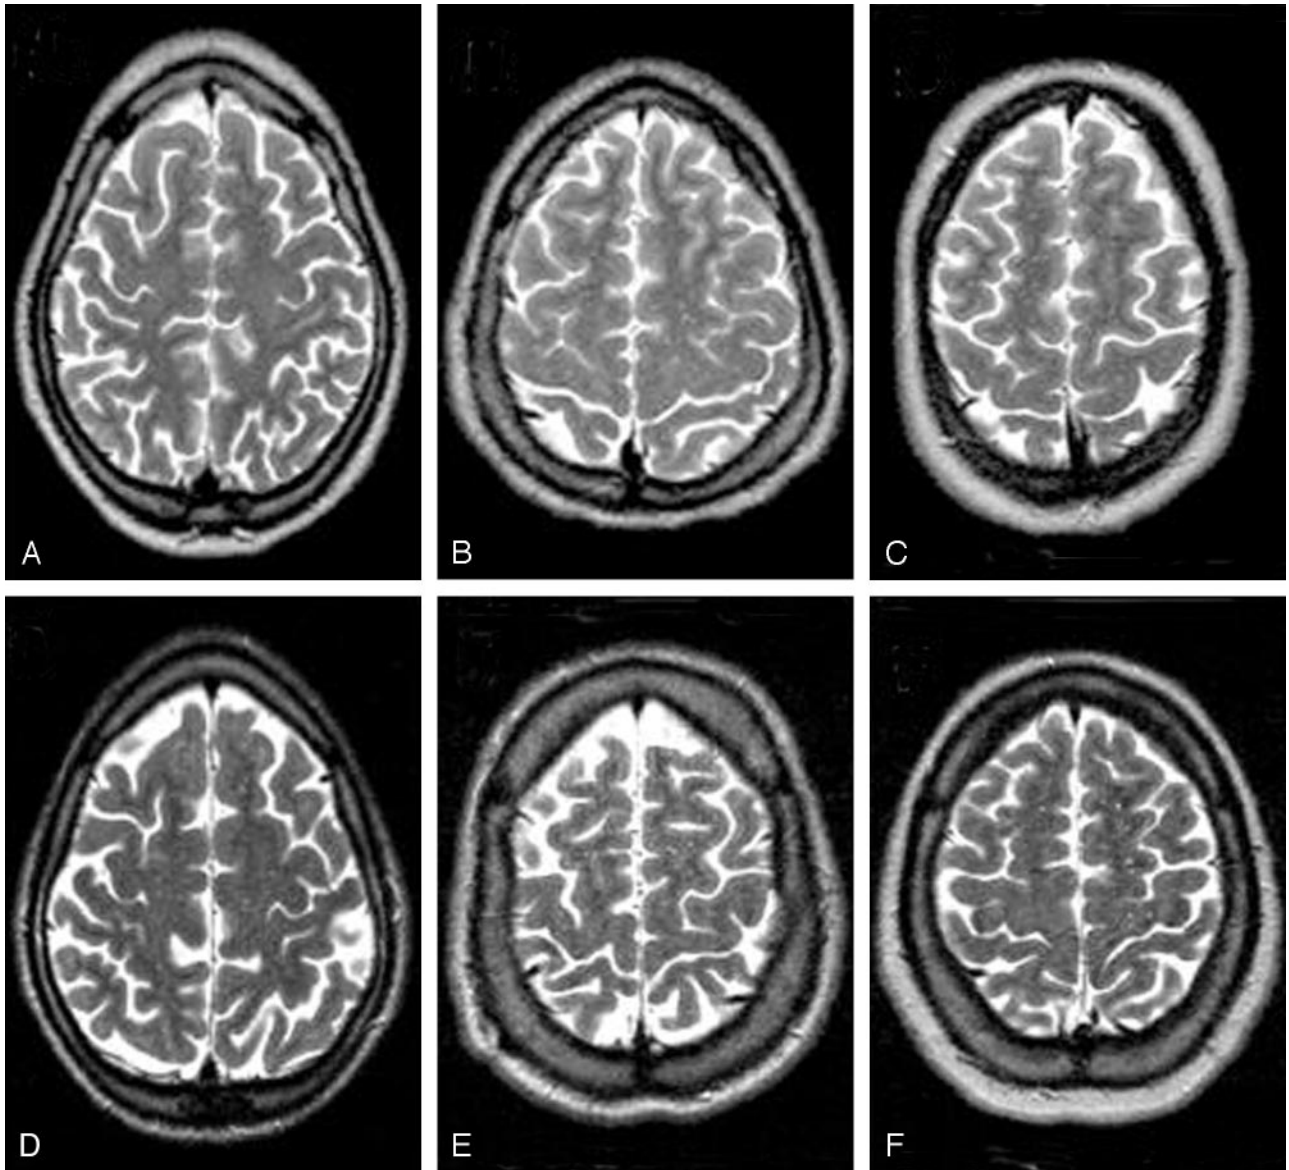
Axial high-convexity T2-weighted images (TE/TR = 119/7900) from younger (A–C) and older (D–F) subjects. Note numerous enlarged VRS in B–F and their absence in A.
